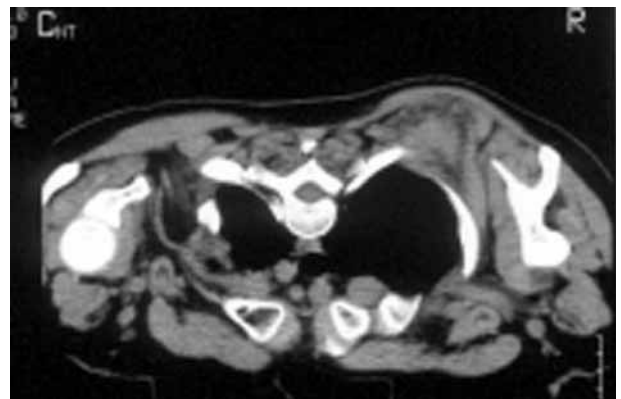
An enhanced axial CT in prone position showing an encapsulated soft tissue density largely surrounded by fat. The mass is bordered posteriorly by the trapezius muscle, antero-laterally by the serratus anterior muscle and medially by the ribs.
